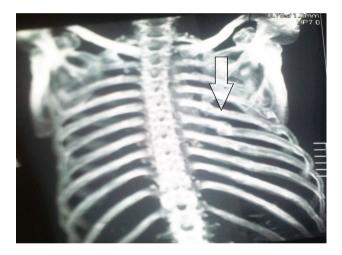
CT Scan: multiple rib fractures.
